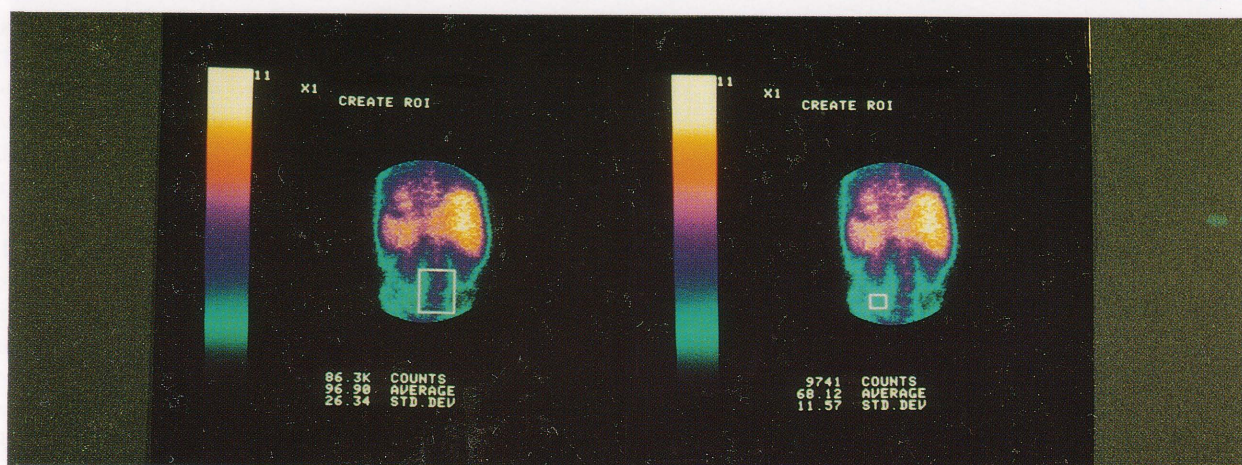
Immunoscintigrams of the bone marrow region. ROI in the left side image was used in calculating the bone marrow uptake and that in the right side image was served as a reference in eliminating the background count included in the bone marrow ROI.
